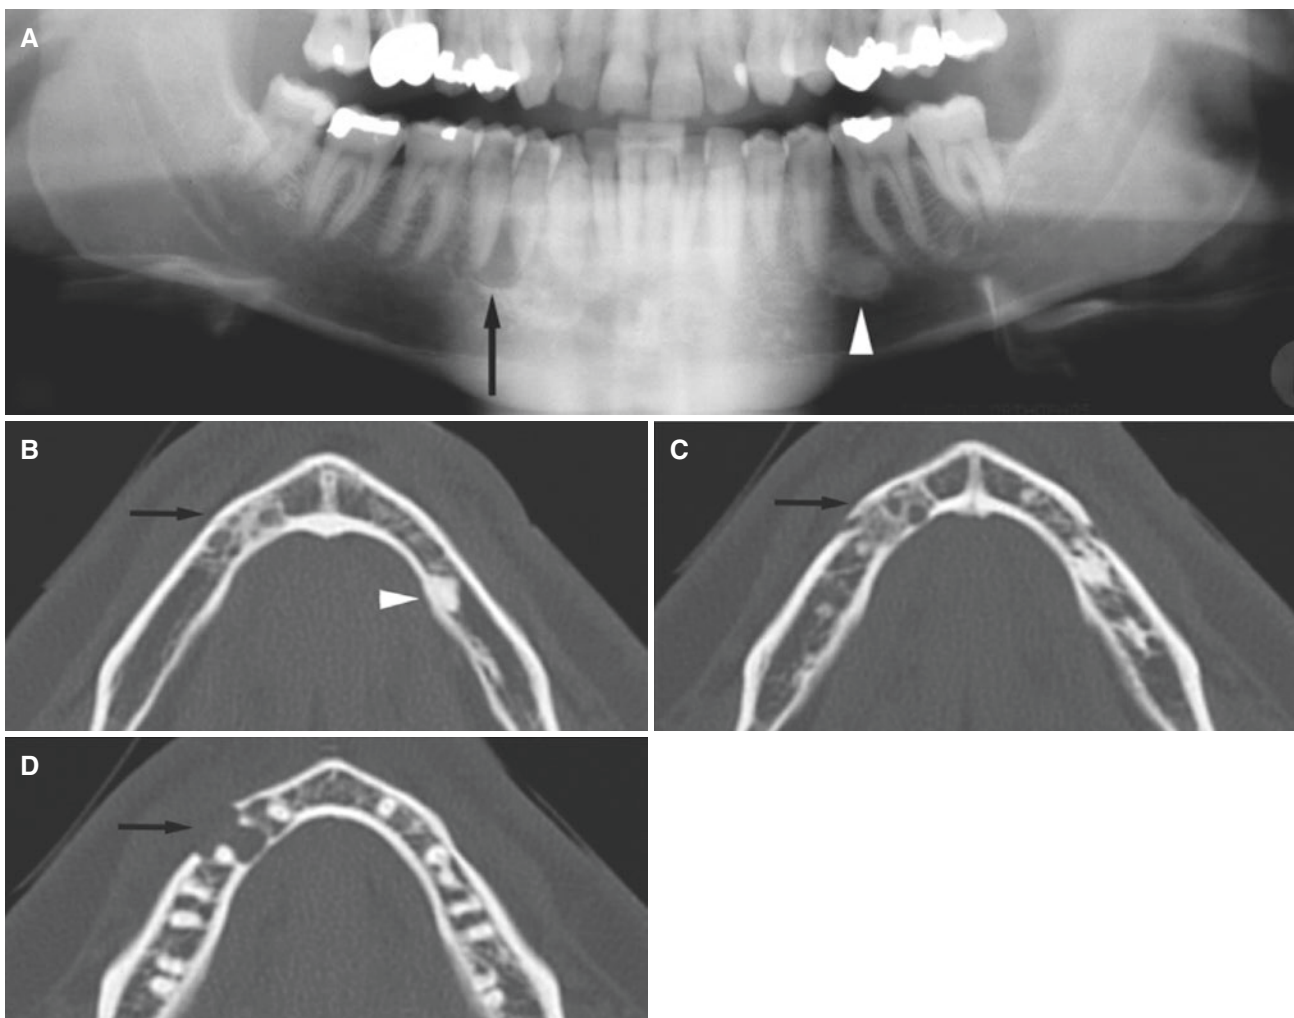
Ameloblastoma, recurrence, mandible; same patient as in Fig. 3.26, 2 years after surgery. (A) Panoramic view shows small unilocular radiolucency (*arrow*) and small radiopacity as an incidental finding (*arrowhead*). (B) Axial CT image shows multilocular radiolucency caudal to mental foramina with diffuse osteosclerosis (*arrow*)
